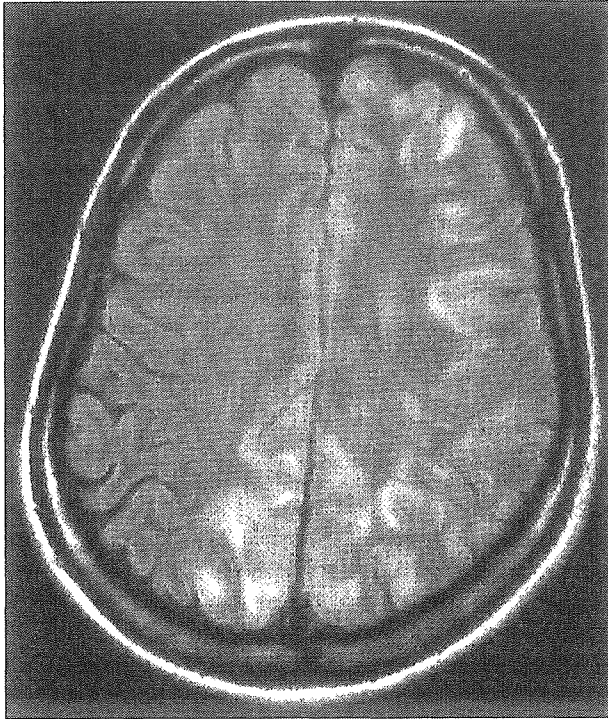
Fluid-attenuated inversion recovery (FLAIR) image showing parietal and occipital, but also some typical frontal lobe edema. (Case 1)
